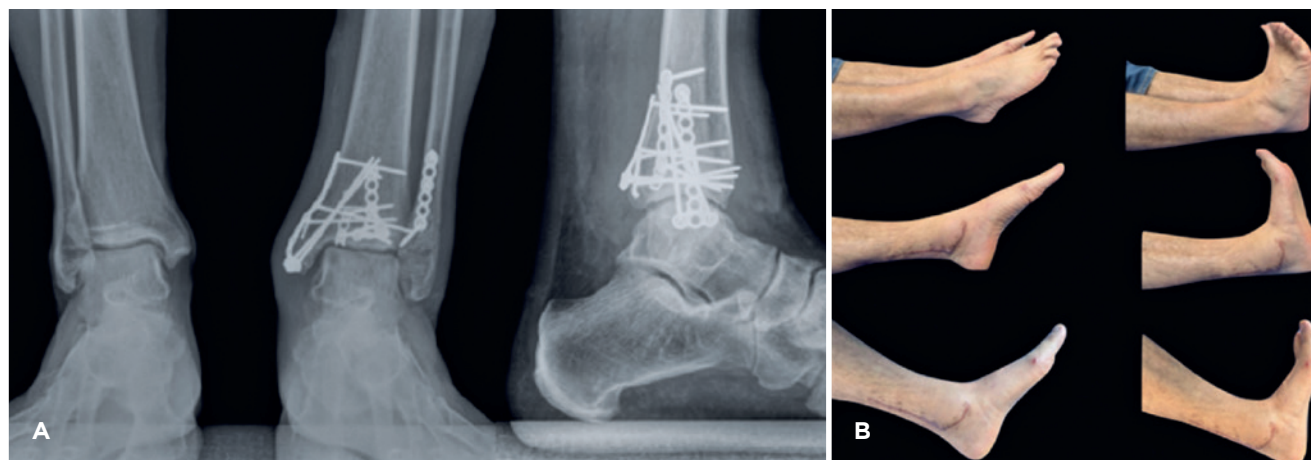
(A) Full-weight-bearing follow-up radiographs four months after surgery. (B) The surgical wound was completely healed at four months postoperatively, and ankle motion was clinically functional and nearly symmetrical when compared with the contralateral side.
